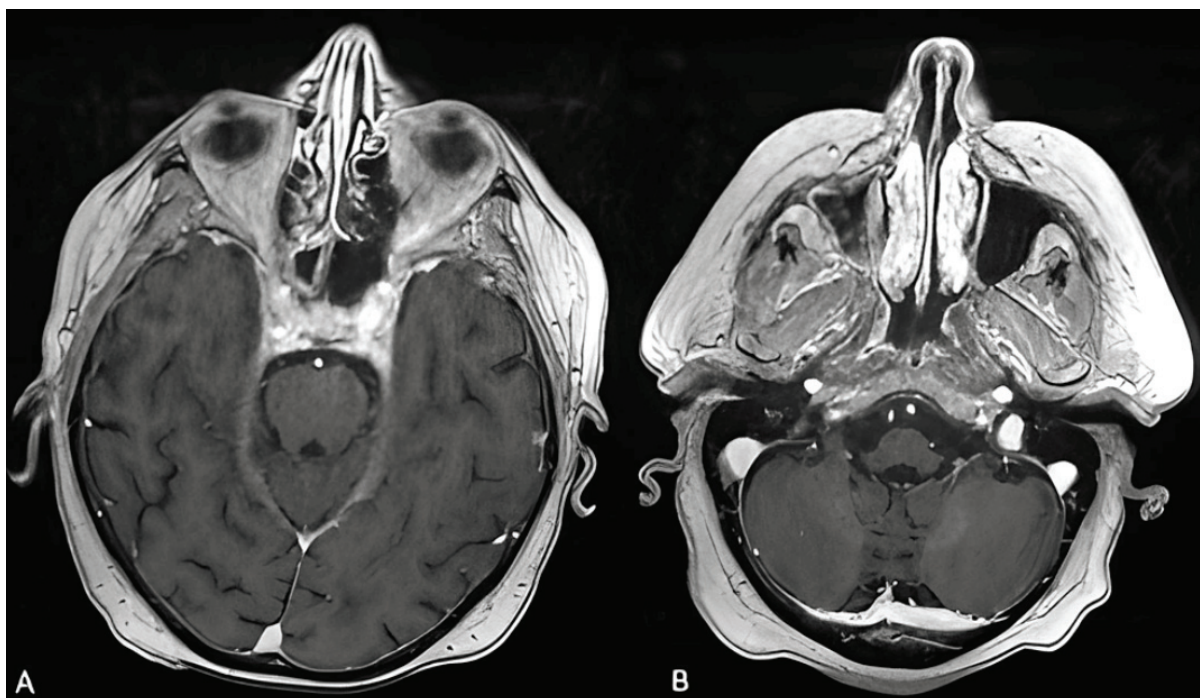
A: A brain MRI of case 2 with evidence of complete intracranial parenchymal response. B: Brain MRI scan with evidence of complete leptomeningeal response.
